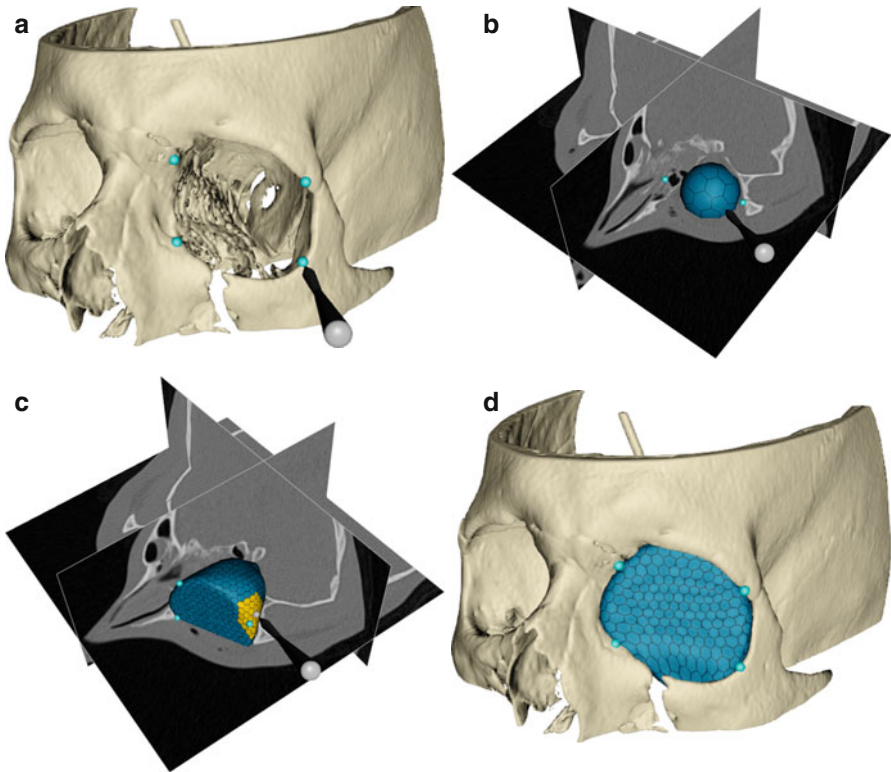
Overview of the semi-automatic orbit segmentation method. (a) The user defines a bounding plane at the orbital opening by placing four landmarks (*blue dots*) on the perimeter of the orbital opening. Haptic feedback facilitates the landmark positioning. (b) The user initializes a deformable simplex mesh (*blue*) as a coarse sphere inside the orbit. (c) The simplex mesh is deformed, using information from the underlying CT data, to fit the orbit. If necessary, the user guides the deformation process interactively, using the haptic stylus. (d) Resulting orbit segmentation
